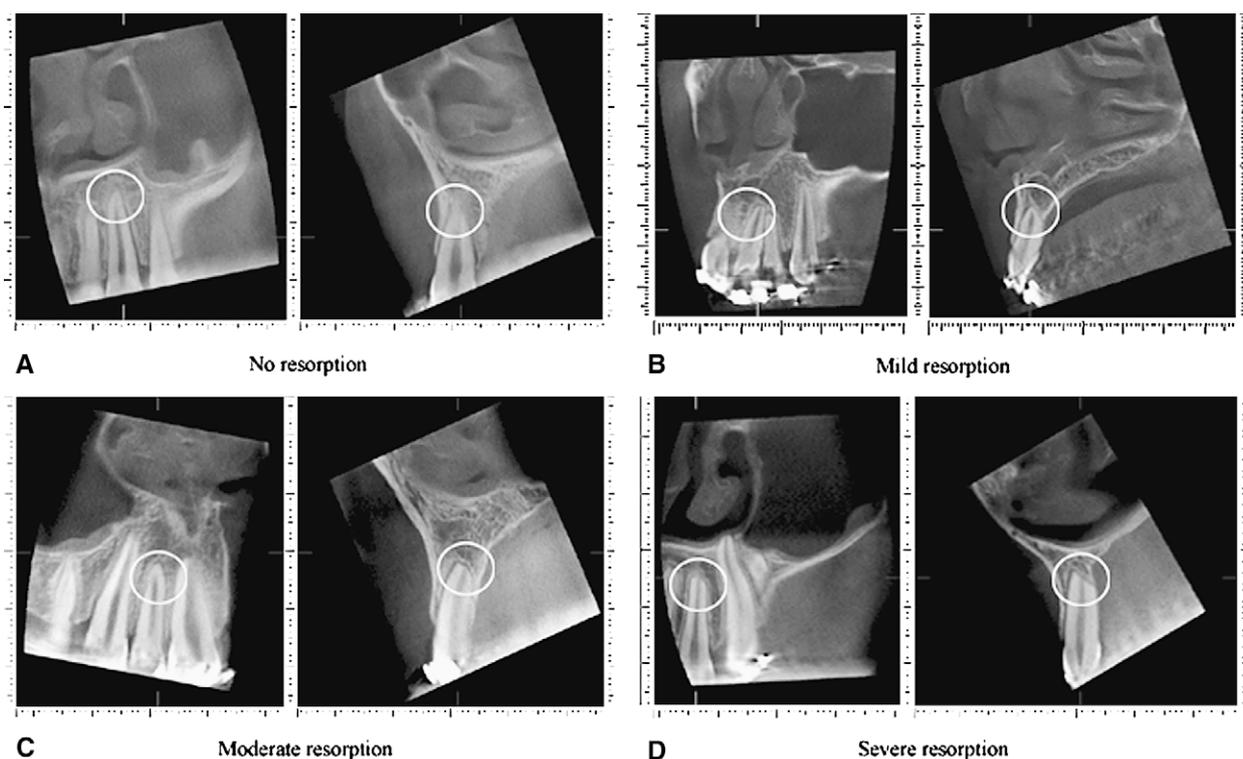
Index for evaluation of root resorption in the CBCT: A, 0, no resorption in tooth 22; B, 1, mild resorption in tooth 21; C, 2, moderate resorption in tooth 12; D, 3, severe resorption in tooth 22.
